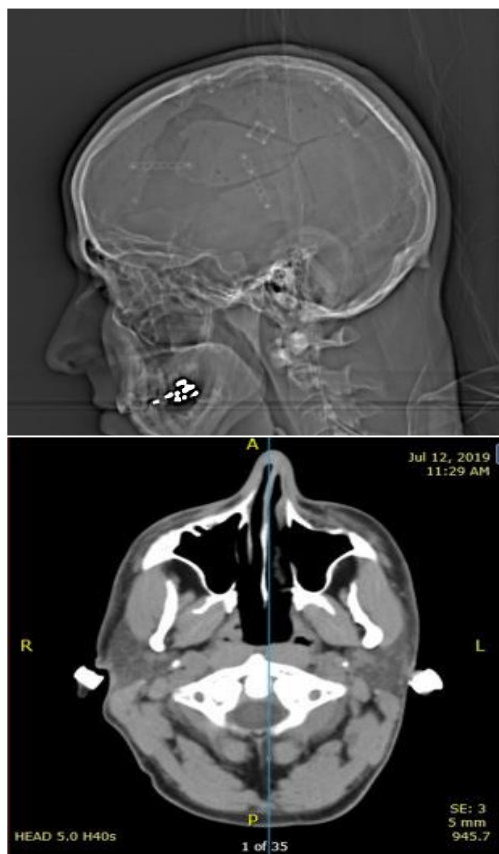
CT of head without contrast post-surgery showing multifocal comminuted left-sided calvarial fractures and postsurgical changes from left partial craniotomy with minimal residual subdural hematoma.
